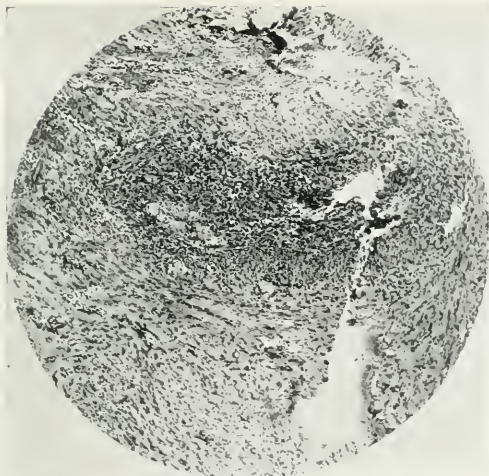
Pathol. No. 30616. Case 1. Periosteal sarcoma, ossifying type. Microphotograph, low power, of infiltrated muscle outside of periosteal growth. For gross see Figure 3, for x-rays see Figures 1 and 2.
